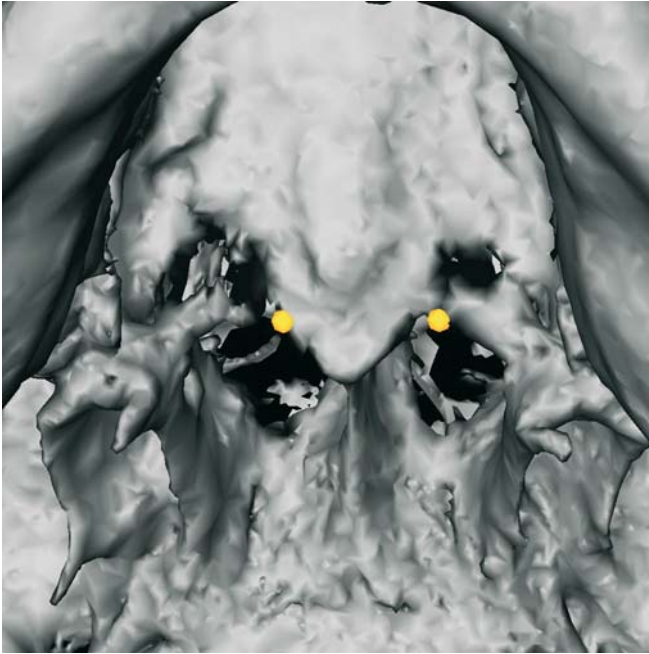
Posterior Maxillary Point (PMP_r – PMP_l) landmarks. Exocranial skull base view (3-D CT, patient K.C.)
